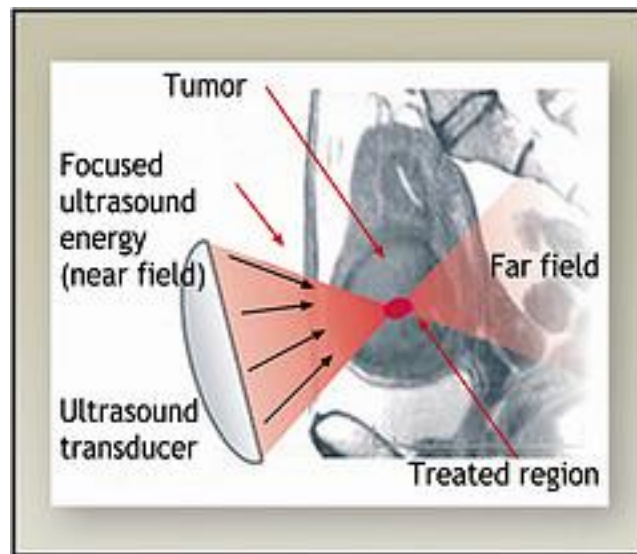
Focused ultrasound on tumor treatment [89].
